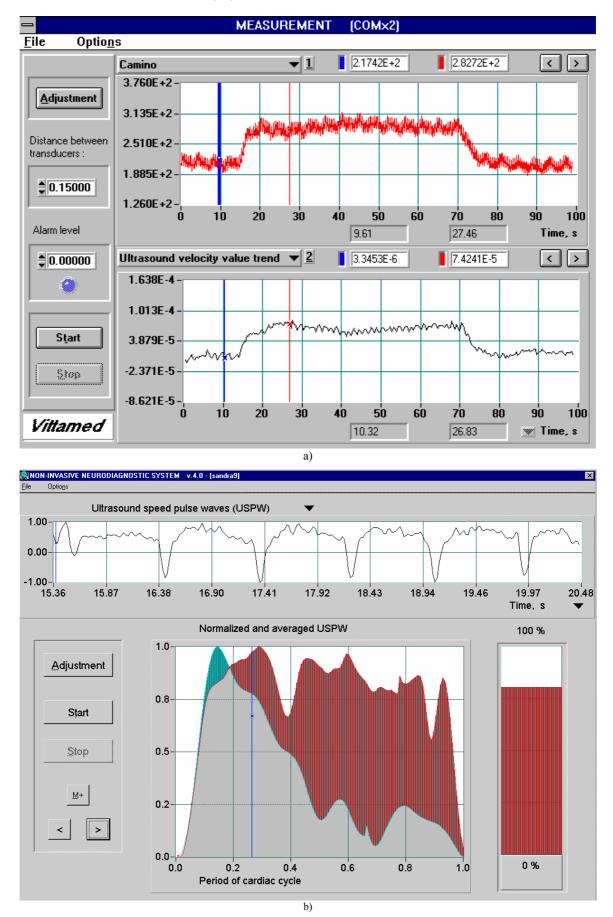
The virtual panels of Vittamed device: a) is the simultaneous monitoring of the cerebraovascular reaction on a bed tilting test with the invasive ICP (Camino) monitor and non-invasive ultrasound speed monitor for a head-injured patient in ICU. b) is the non-invasive monitoring of ultrasound velocity pulse wave and the analysis of pulse wave evolution for a spinal cord-injured patient in ICU
